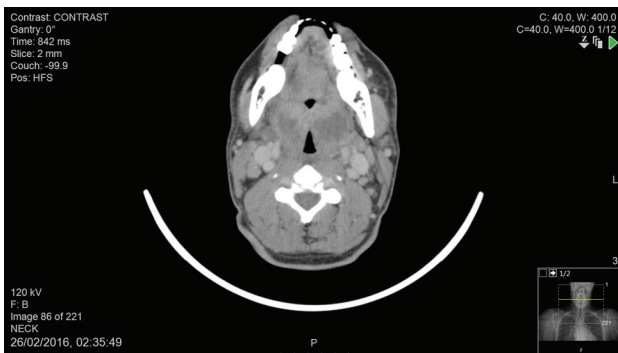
A transverse section of computed tomography showing bilateral low-attenuation masses at the tonsils.
